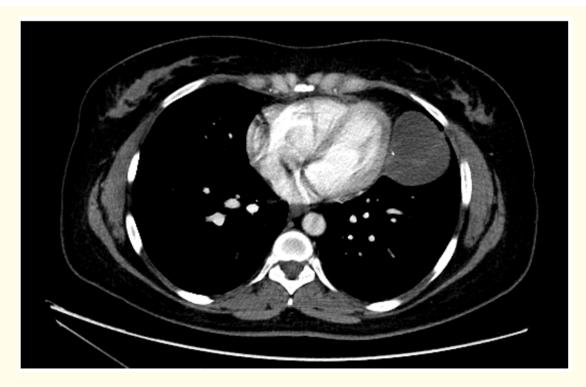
Axial intravenous contrast enhanced CT scan of the chest demonstrates left paracardial cyst with enhancing septation and tiny calcification originates from the left phrenic nerve.
